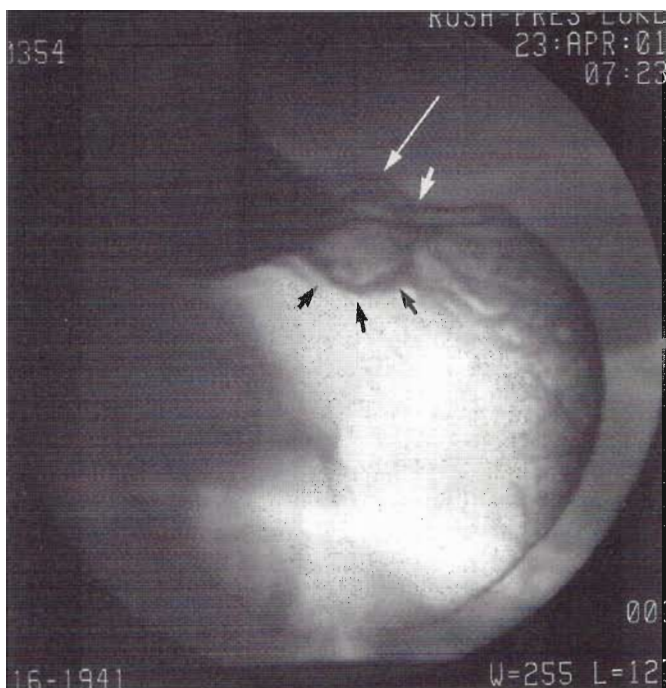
Digital spot film from an upper gastrointestinal examination demonstrating the gastric mass located in the proximal stomach. Small arrows outline a smooth mucosal surface. The short white arrows point to the classic “right angle deformity” indicating a submucosal location by radiographic criteria. The long white arrows show the bulging contour deformity on the external surface of the stomach.
